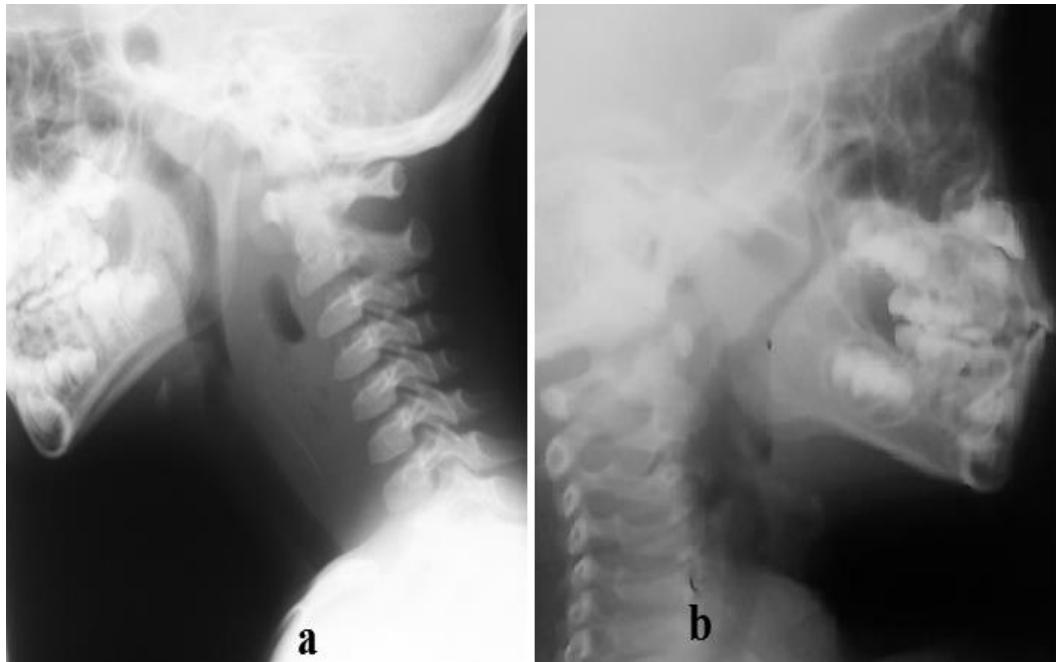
Plain radiograph of the pharynx. a. Retropharyngeal abscess from swallowed fish bone. Note the lucency within the soft tissue mass anterior to the cervical vertebrae due to gas within the abscess. b. Severe narrowing of the airway due to adeno-tonsilar hyperplasia in a child.
